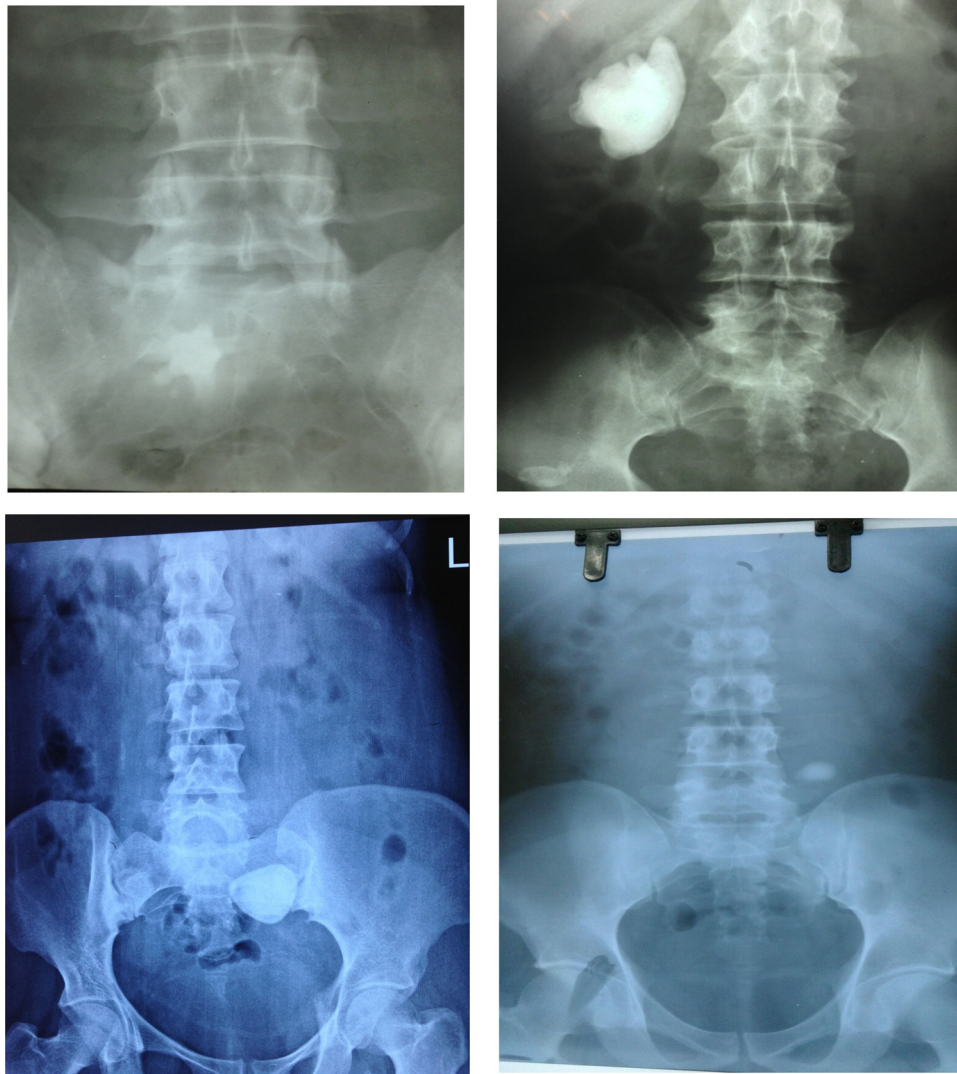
Radiographs of KUB region of all 4 patients.
